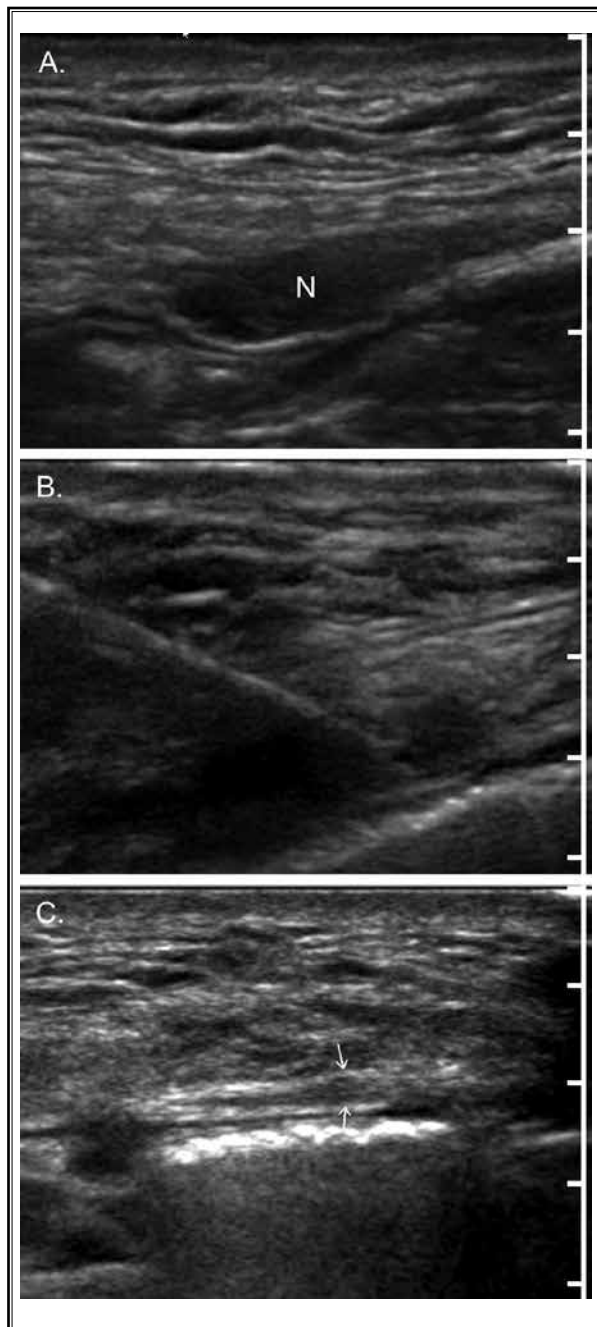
US-guided alcohol neurolysis for an inguinal neuroma. A 68-year-old man with chronic right inguinal pain refractory to medical and injected steroid therapy. A. Oblong right inguinal neuroma (N) measuring up to 1.2 cm in size. B. Satisfactory needle and injectate placement into the inguinal neuroma. C. A follow-up US obtained 8 months following alcohol neurolysis showed a small residual neuroma measuring up to 0.7cm. US, ultrasound.
